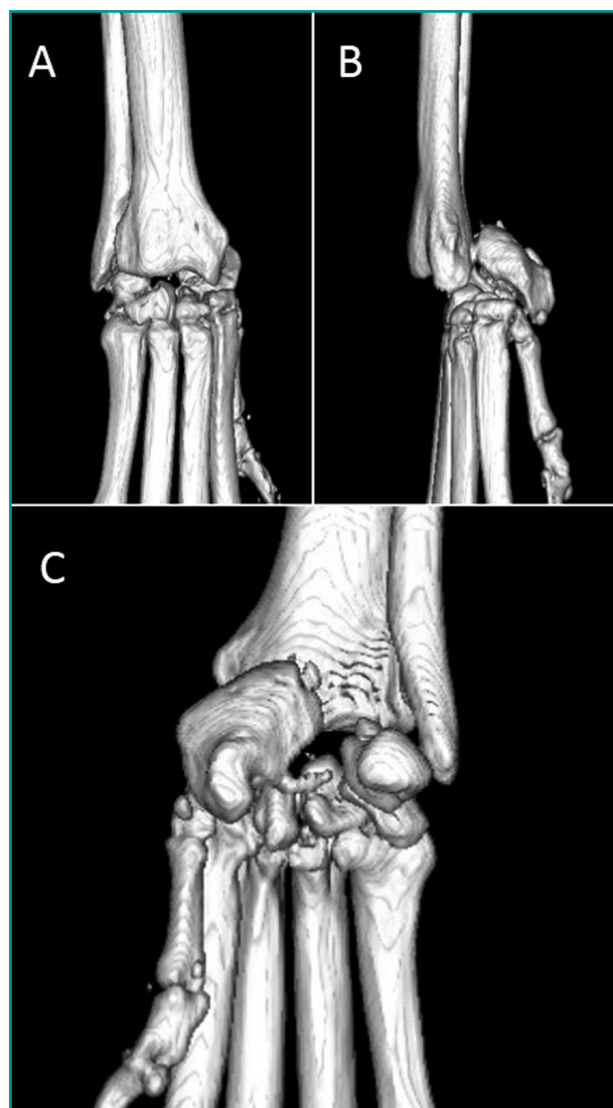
Computed tomography images with 3D reconstruction of the right anterior carpus of case 1 in dorsal (A), lateral (B) and palmar (C) views.
